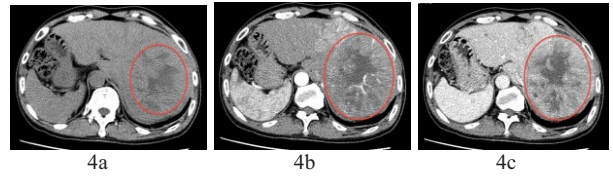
Sample MR images of late stage liver cancer with the ROI selected. Where 4a is the image of  $S_0$ , 4b is image for the  $S_h$  and 4c is the  $S_p$  image.
